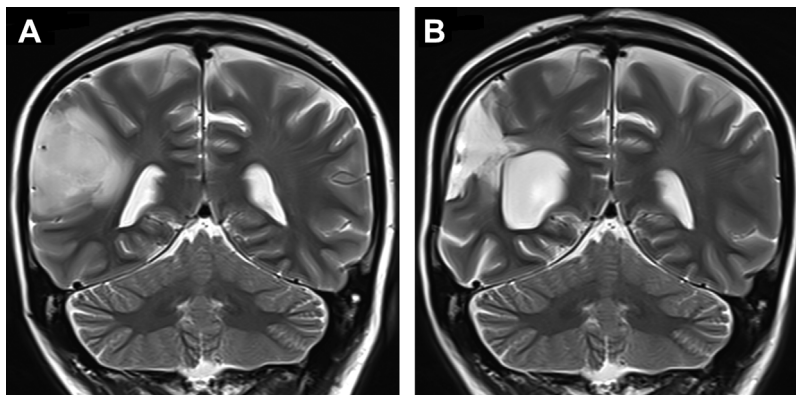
A. Coronal slice of T2-weighted preoperative MRI. B. Coronal slice of T2-weighted postoperative MRI.
